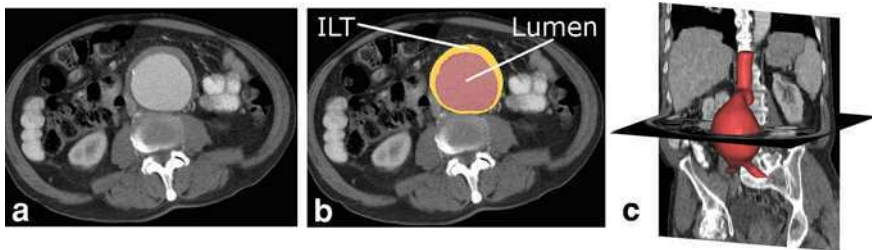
Procedure of 3D reconstruction from CT scan. a Typical CT scan of an AAA through the maximum diameter region. b Image after thresholding and segmentation of the region of interest with the lumen shown in *yellow* and the intraluminal thrombus (ILT) shown in *blue*. c Resulting 3D reconstruction of the AAA
